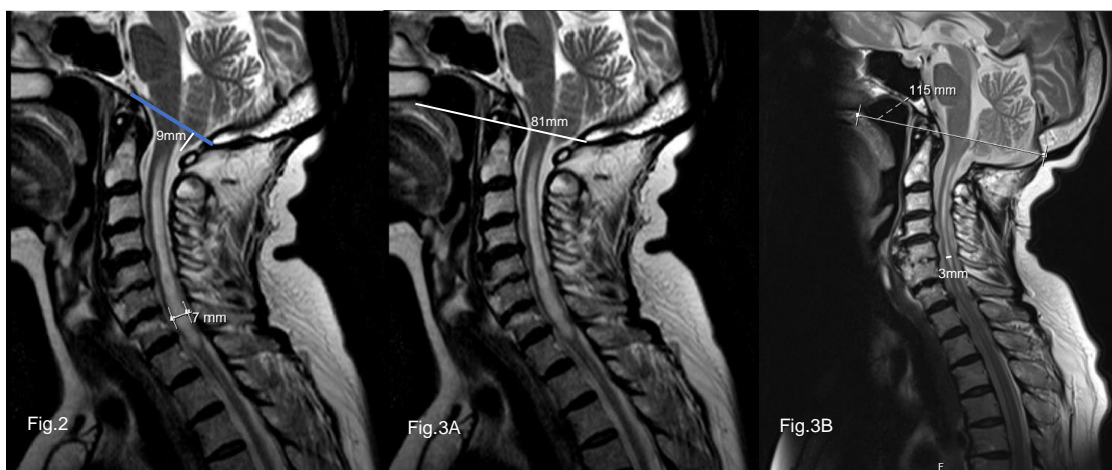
Mid-sagittal T1 MRI of a patient diagnosed with CM1 with syringomyelia. The blue line indicates McRae's line. The grade of cerebellar tonsillar herniation, in millimeters, is measure below McRae's line (9mm). Sagittal diameter of the syringomyelic cavity before surgery was 7mm. Fig.3A - Mid-sagittal T1 MRI of the same patient. The white line indicates the length, in millimeters, of occipitopalatine line before surgery (81mm). Fig.3B - Mid-sagittal T2 MRI of the same patient. The white line indicates the length, in millimeters, of occipitopalatine line after surgery (115mm). Sagittal diameter of the syringomyelic cavity after surgery was 3mm.
